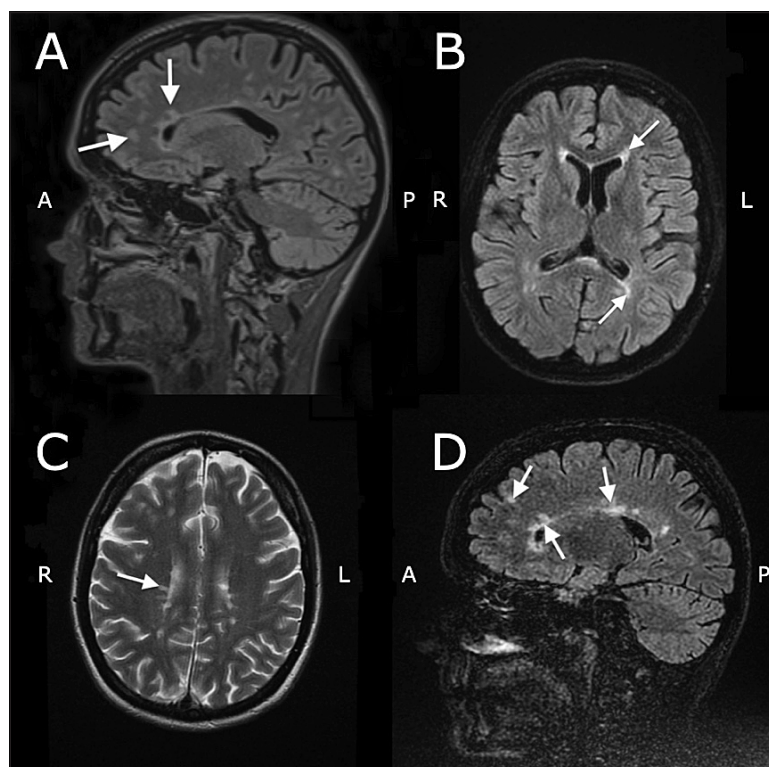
Brain MRI (performed in 2018 and 2019).
